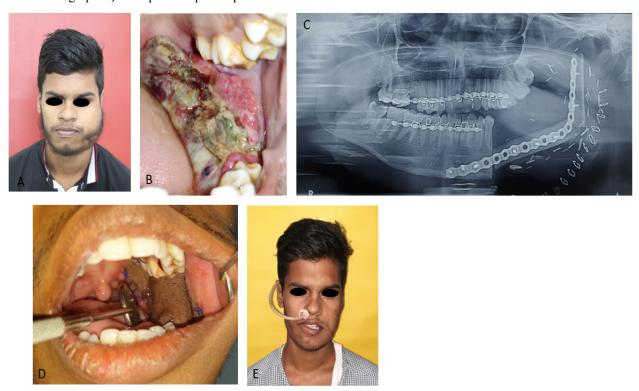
Case of Ameloblastic Fibroma A) Preoperative profile picture B) Preoperative Lesion C) Postoperative Radiograph D) Postoperative flap Inset E) Postoperative profile picture.
